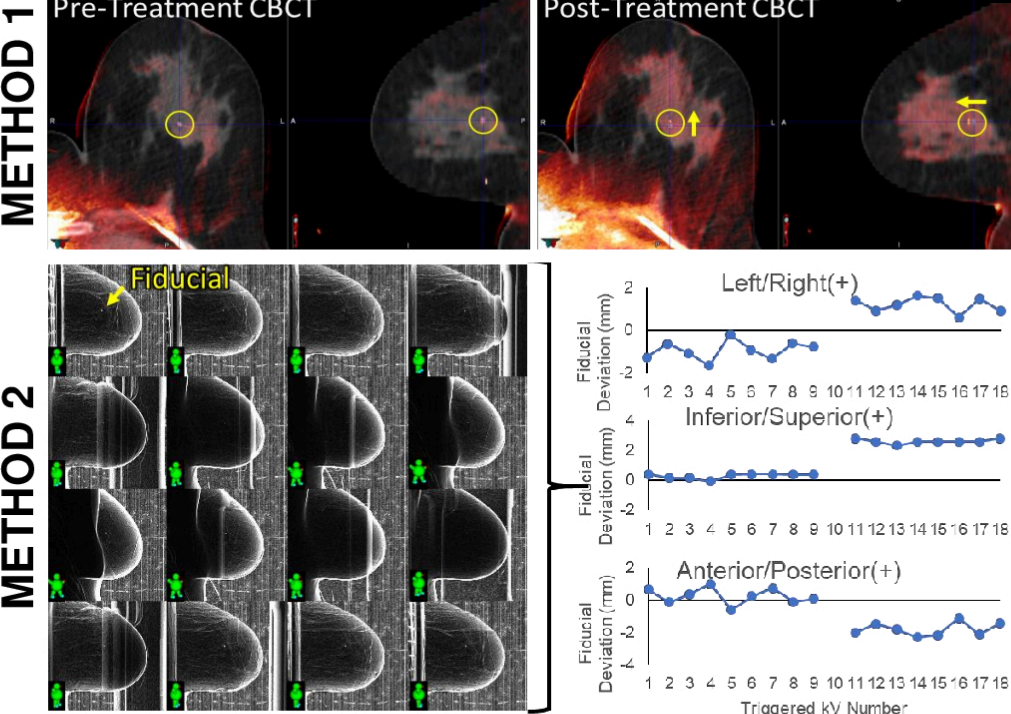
Representative patients from Method 1 (top row) and method 2 (bottom row). In method 1, the pre- and post-treatment CBCT are used to determine the total intrafraction movement of the fiducial by calculating the difference pre- to post-treatment in each direction. In method 2, the fiducial is located on the 2D triggered kV images acquired during treatment (bottom row, left) and then the 3D position reconstructed using a maximum likelihood estimation method (bottom row, right). From this we can recover the intra-fraction mean and standard deviation of the fiducial error. Note that the kV images in method 2 have a gradient filter applied for better visualization of the fiducial.
